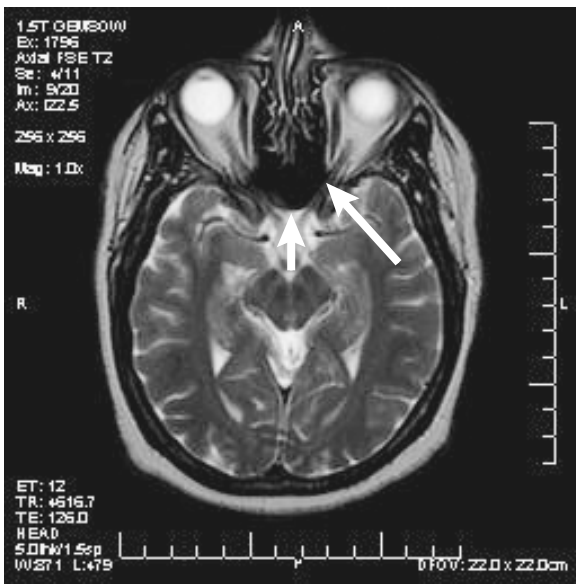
Left optic nerve (long arrow) and optic chiasm (short arrow) as seen on magnetic resonance imaging.
